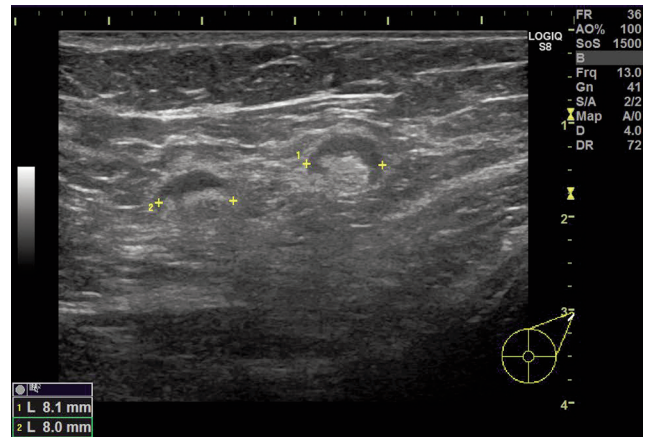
Ultrasonography (June 2021) shows an axillary lymph node of 8.1 mm length with a thickened cortex caused by previous COVID-19 vaccination.
